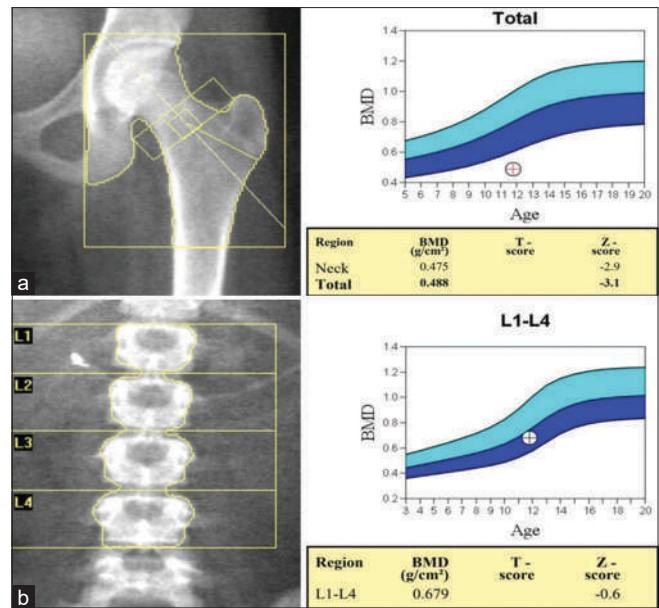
Dual energy X-ray Absorptiometry scan showing bone mineral density. (a) Lumbar spine, (b) Hip: Severe osteopenia. (Z-score: < -3.1)
